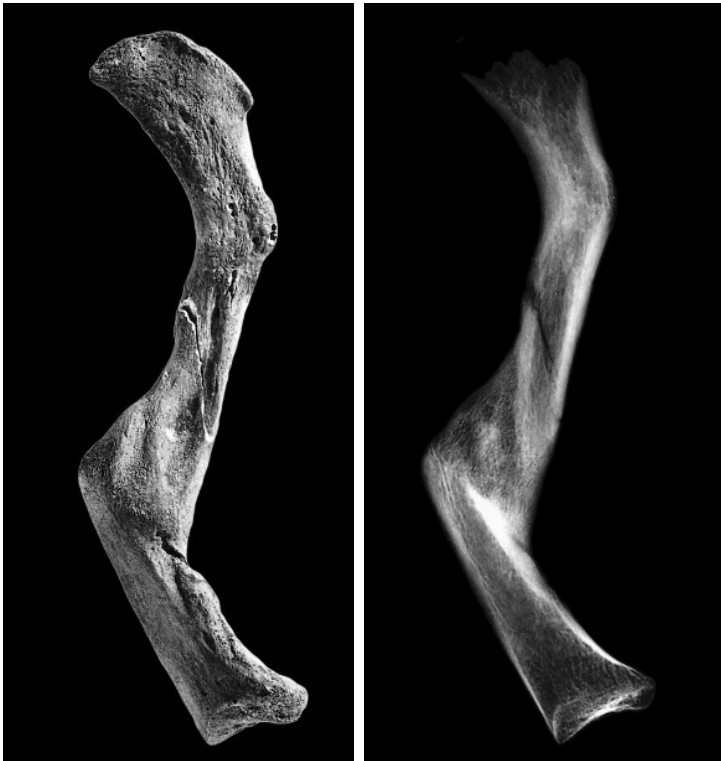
Healed fracture. This left clavicle shows a postmortem fracture (the light-colored bone around the crack visible in this inferior view) and a more medial antemortem fracture that has healed. The original shaft surfaces are joined by a bony callus. The radiograph shows that the medial end of this clavicle rotated counterclockwise relative to its lateral end, resulting in a dramatic misalignment of the fractured pieces during and after healing. Prehistoric, California. One-half natural size.
